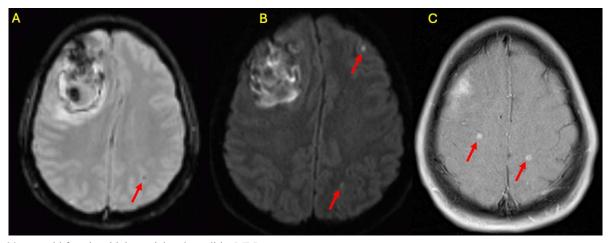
30-year-old female with bacterial endocarditis- MRI
